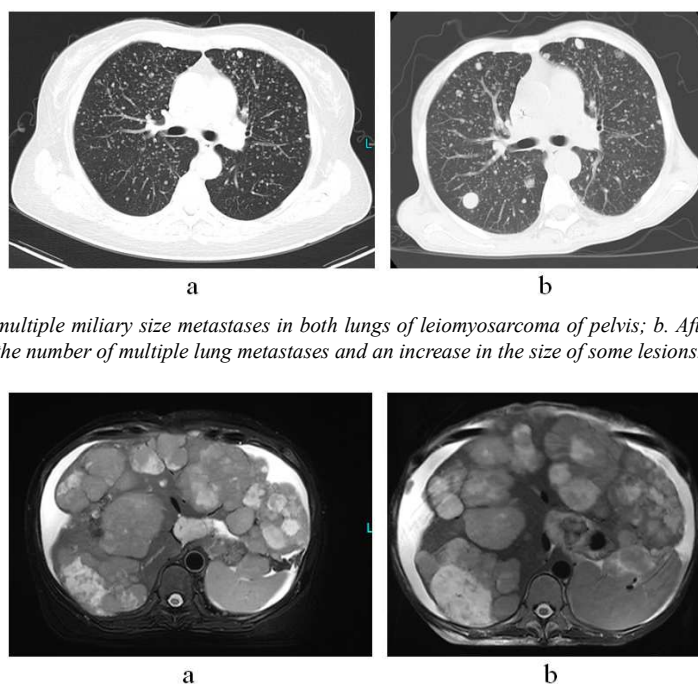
a. Chest CT scan showed multiple miliary size metastases in both lungs of leiomyosarcoma of pelvis; b. After 9 months of treatment with Arotinib, CT scan showed a slight decrease in the number of multiple lung metastases and an increase in the size of some lesions.
